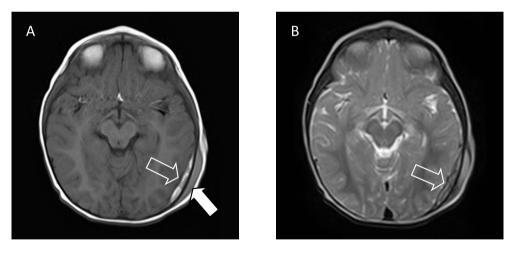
Case 6. Axial T1-weighted MR image of a 1-year-and-3-month-old boy who fell from a bunk bed. Information not available to the participating radiologists: The history revealed that the boy was put on a bed (1.60 meter high) by a sibling. He fell of and cried immediately; parents took him to the GP but were referred to the ED because of swelling on the head. The child was admitted to the pediatric ward for one night for observation. Parents noticed a new swelling of the head after some days, and therefore a MRI was performed on day 9. No other trauma was described. MR shows a mixed intensity SDH along the left convexity (open arrow). There is a significant subcutaneous haematoma present (arrow). Figure 6b. Axial T2-weighted MR image of the same boy also shows a mixed intensity SDH (open arrow).
